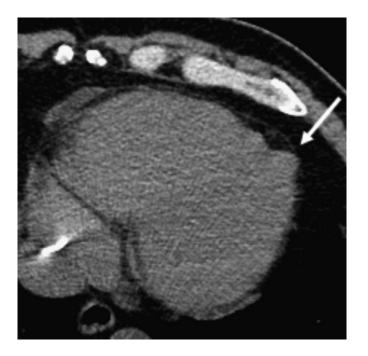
A CT scan of the chest again demonstrated the apical aneurysm (indicated with an arrow) and an implantable cardiac defibrillator but was otherwise unremarkable.
